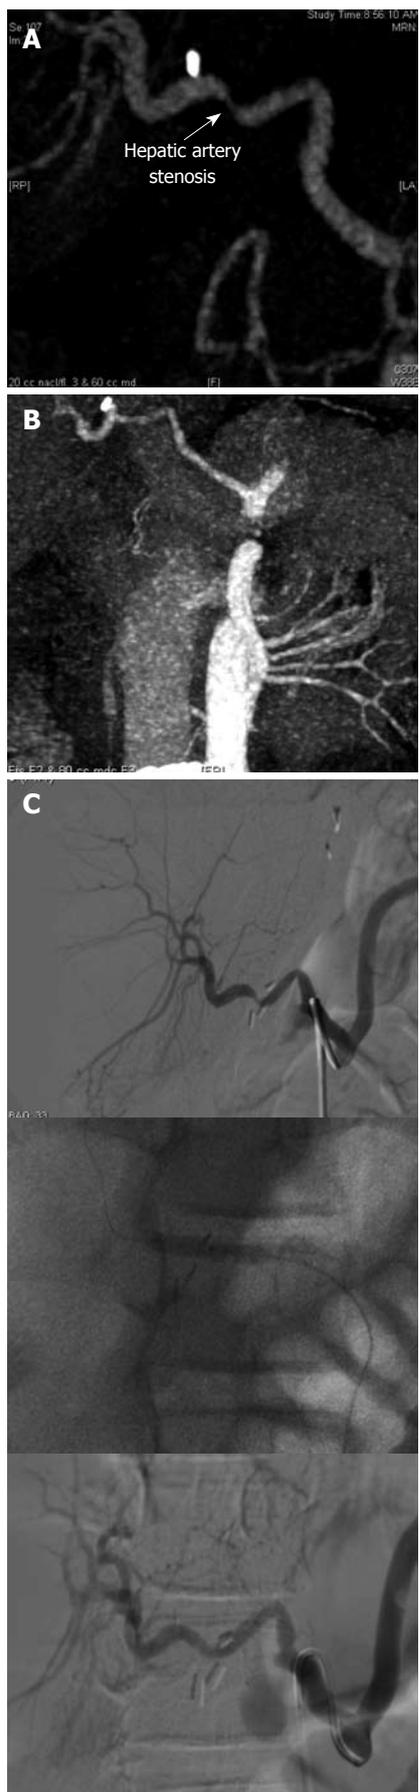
A case of hepatic artery stenosis. Reconstructed computed tomographic angiography demonstrating severe hepatic artery stenosis in an extended right graft recipient (A), and complete resolution of the stenosis 6 mo later (B), after stenosis treatment by early interventional guided balloon angioplasty (C).
